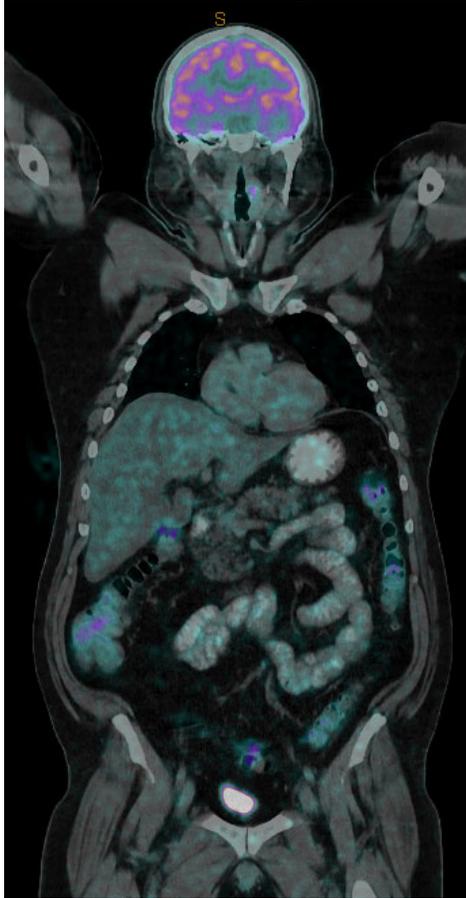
Wholebody (truncated at hips) ^{18}F FDG PET/CT at 60 minutes post intravenous administration.
